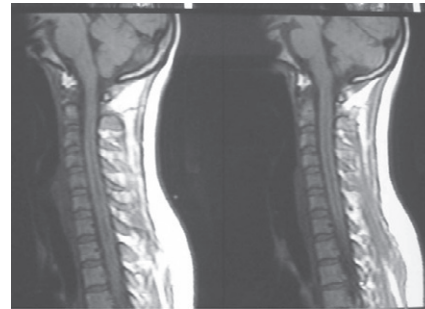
MRI (T1-weighted sagittal image) showing cervical syringomyelia
